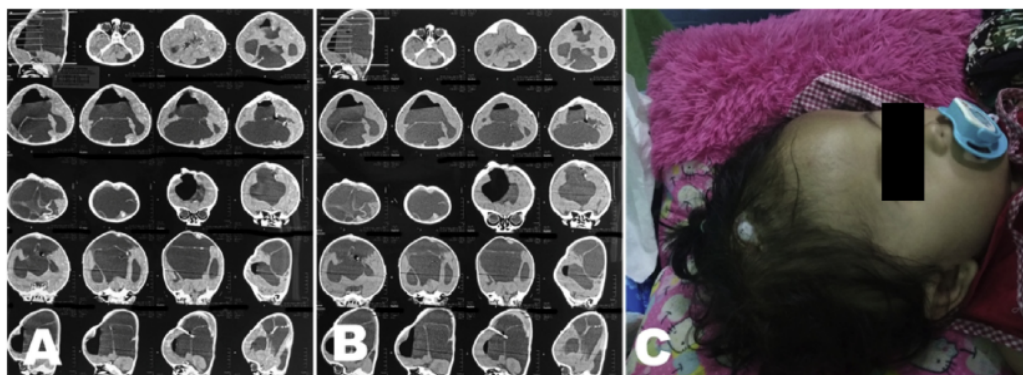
The second case, 15-month-old girl baby comes with a diagnosis of hydrocephalus with VA shunt. The second case; A and B Pre procedural CT Scan; C. Pre procedural clinical image showing tube protrusion on scalp.
